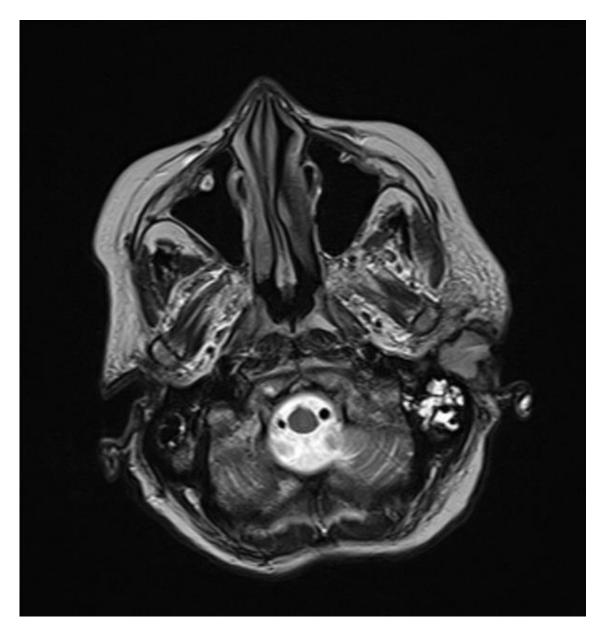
T2 TSE MRI image of the temporal bones.
